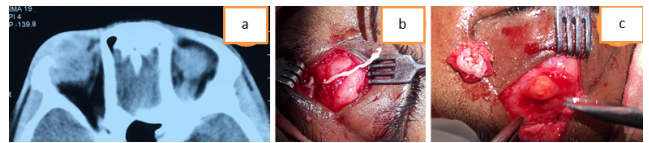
a: Axial image of CT scan of the orbit showing a ill-defined heterogenous lesion within a hypodense area in the right upper eyelid. b: Extracting the live worm from the cystic cavity, and c: Showing the excised cystic wall away from the operating area of the right upper eyelid.
